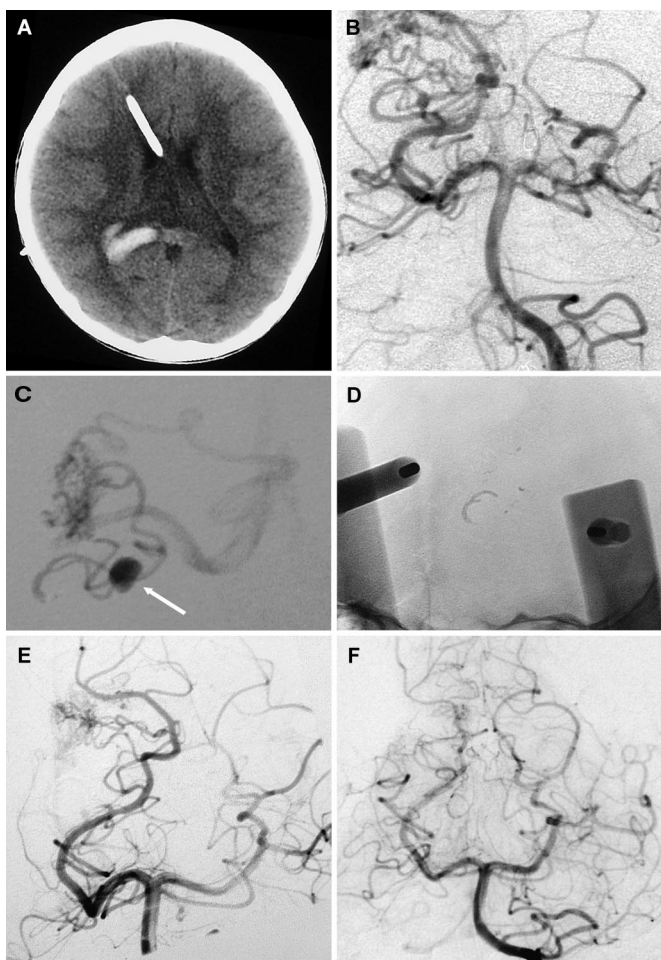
Targeted therapy of an intranidal aneurysm with hemorrhage. A, computed tomographic scan demonstrating a small amount of parenchymal hemorrhage within the right major forceps and marginating the ependymal surface of the right lateral ventricle. B, conventional angiogram obtained using a catheter positioned within the left vertebral artery demonstrating a diffuse AVM nidus within the right medial parietal and occipital lobes with a small central nidal aneurysm. C, superselective angiogram obtained using a microcatheter positioned within a pedicle of the right PCA better defines the anatomy of the aneurysm (arrow). D, unsubtracted image (acquired in the same projection as the superselective angiogram) obtained after NBCA infusion demonstrating a glue cast distributed within the proximal aspect of the pedicle. E, postembolization angiogram demonstrating complete occlusion of the nidal aneurysm with the residual AVM nidus supplied by small, inaccessible branches of the right PCA. This patient subsequently underwent gamma knife radiotherapy with angiographic cure of the AVM demonstrated on follow-up angiography (F).
